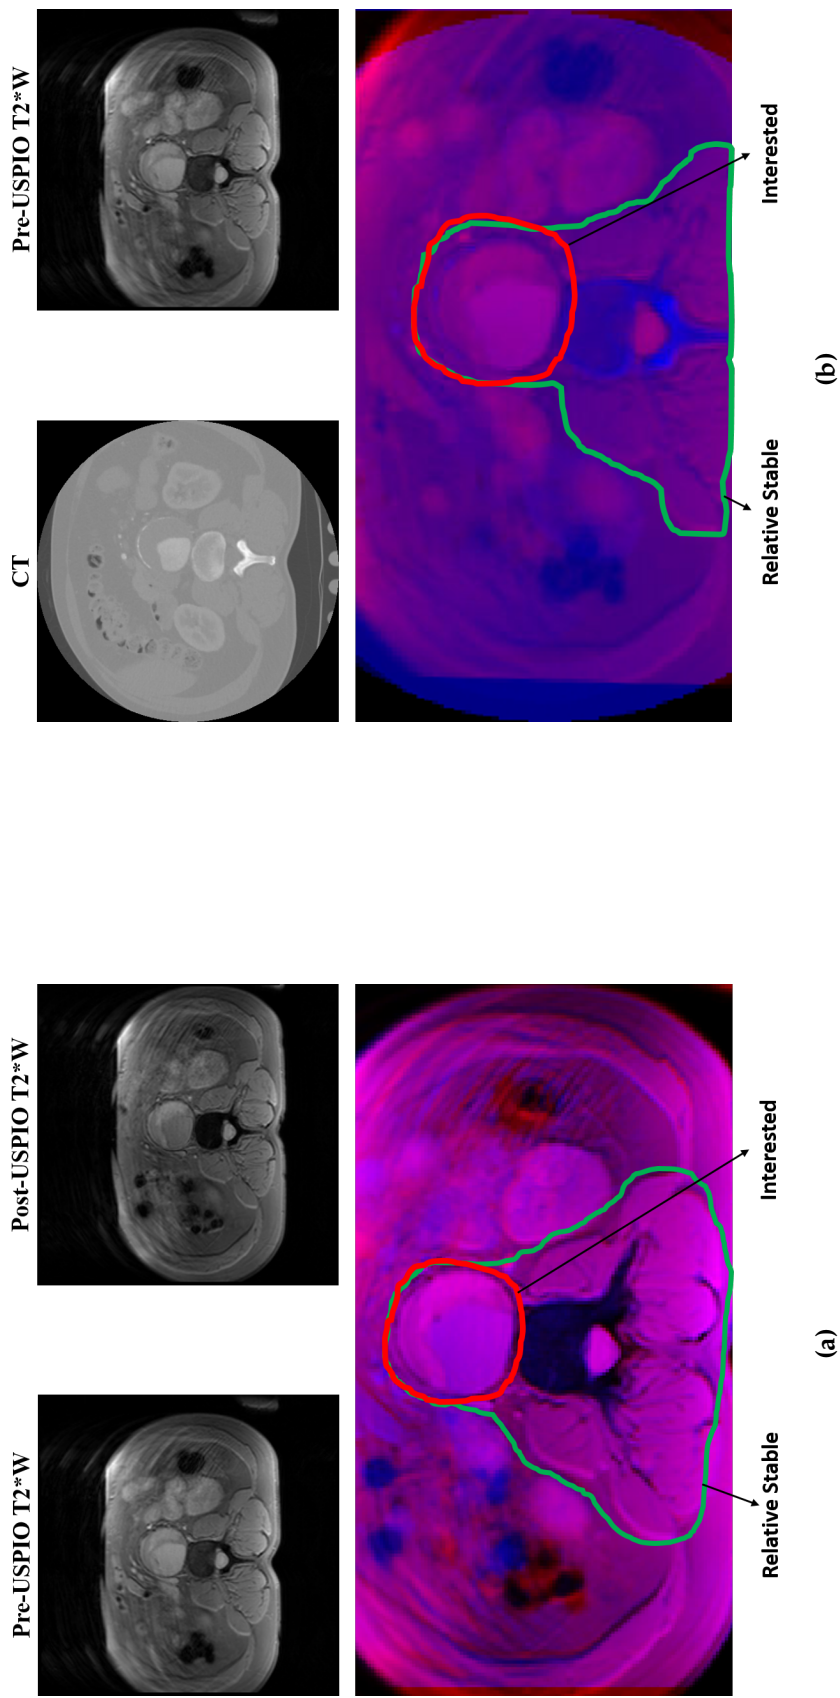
Example of spatially aligned data with the reference and floating slices shown in red and blue color channels. A pair of corresponding MR T2* weighted (T2*W) data acquired in two successive scans is shown on the left and a pair of CT-MR data on the right. The relatively stable area is included in the green contours. The aortic aneurysm of interest in the clinical assessment is included within the red contours.
